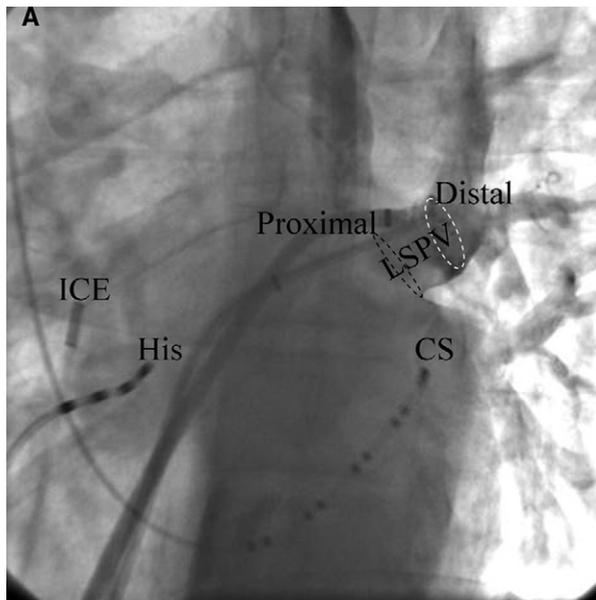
Venography of the LSPV in the LAO projection (A). The dotted black circle represents a Lasso positioned at the antrum after extensive ablation (Proximal), and the dotted white circle represents a Lasso positioned deep in the vein (Distal). The electrograms beneath the venogram represents Lasso recordings from a (B) distal position in the vein and proximally at the antrum (C). Note that deeper in the vein, the far field atrial electrogram is absent. A = atrium; CS = coronary sinus; ICE = intracardiac echocardiography; LSPV = left superior pulmonary vein; PVP = pulmonary vein potential; S = pacing stimulus.
